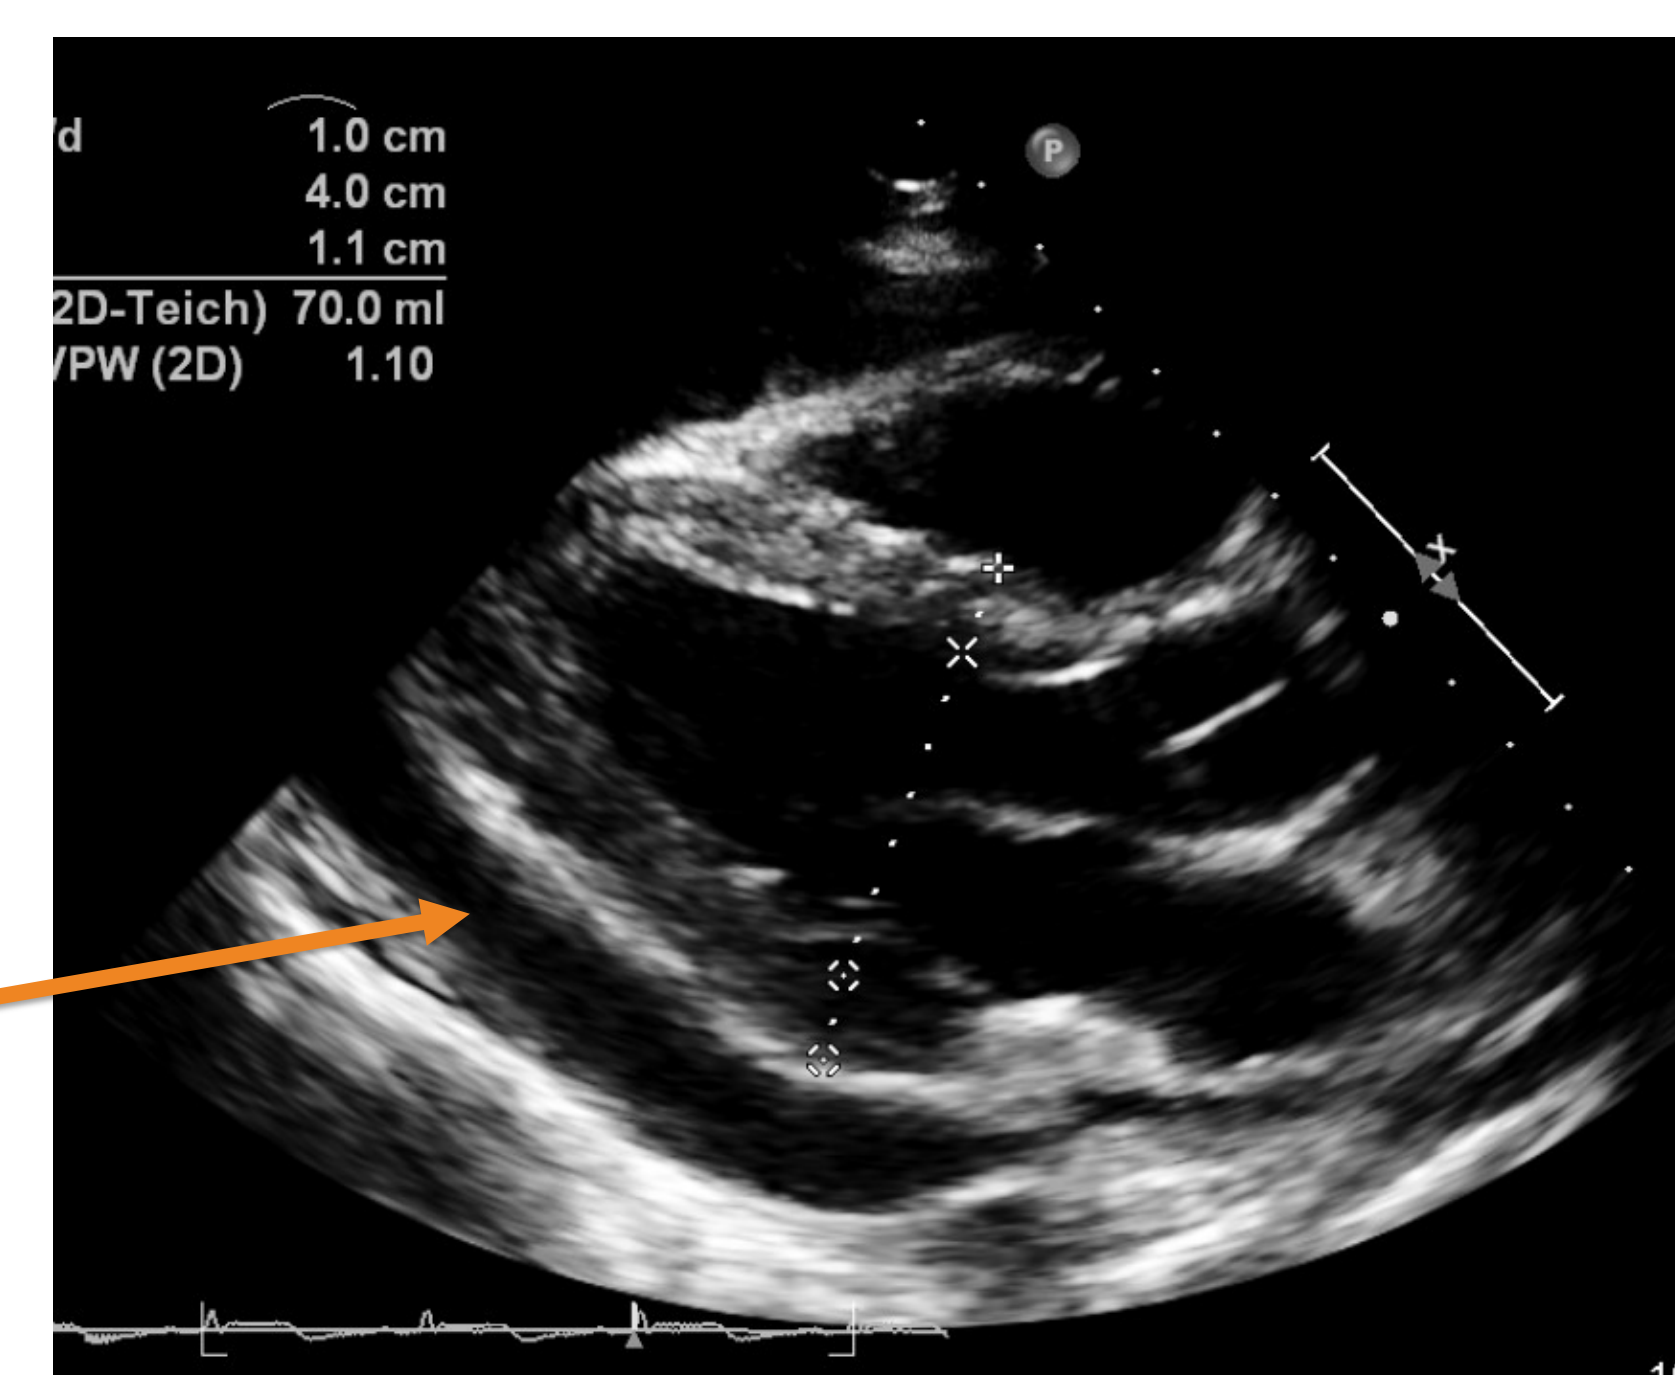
Parasternal long view of the pericardial effusion
